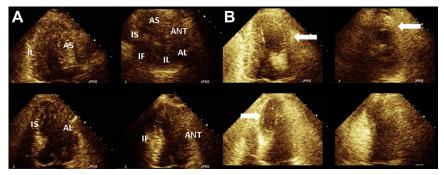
Echocardiographic portion of Fig. 1. Simultaneous 4-view presentation showing all wall segments, including 3-chamber apical (*upper left*), parasternal short axis view (*upper right*), 4-chamber apical view (*lower left*), and 2-chamber apical view (*lower right*). (*A*) Wall segments at rest before exercise. There are no wall motion abnormalities at rest, with an ejection fraction of 60% to 65%. (*B*) Wall segments seen at peak exercise. The anterior and midseptum to distal septum (*arrows*) become severely hypokinetic, suggestive of exercise-induced ischemia in the left anterior descending artery. This finding correlates with the angiogram seen in Fig. 1D. AL, anterolateral; ANT, anterior; AS, anteroseptal; IL, inferolateral; INF, inferior; IS, inferoseptal.
